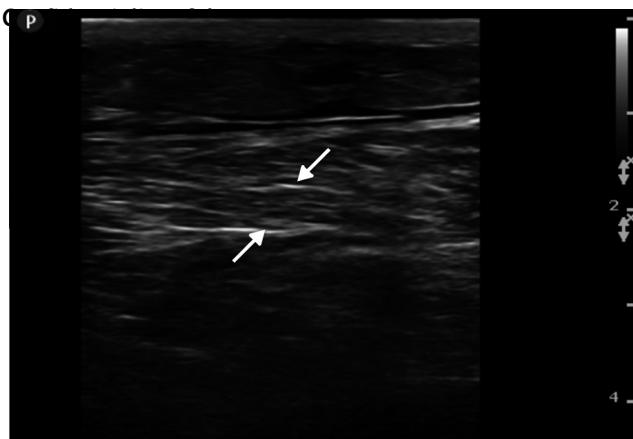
Ultrasound image in 2D of the left rectus femoris muscle showing hyperechoic intramuscular areas and disorganized distribution of the muscle fascicles (arrows).
